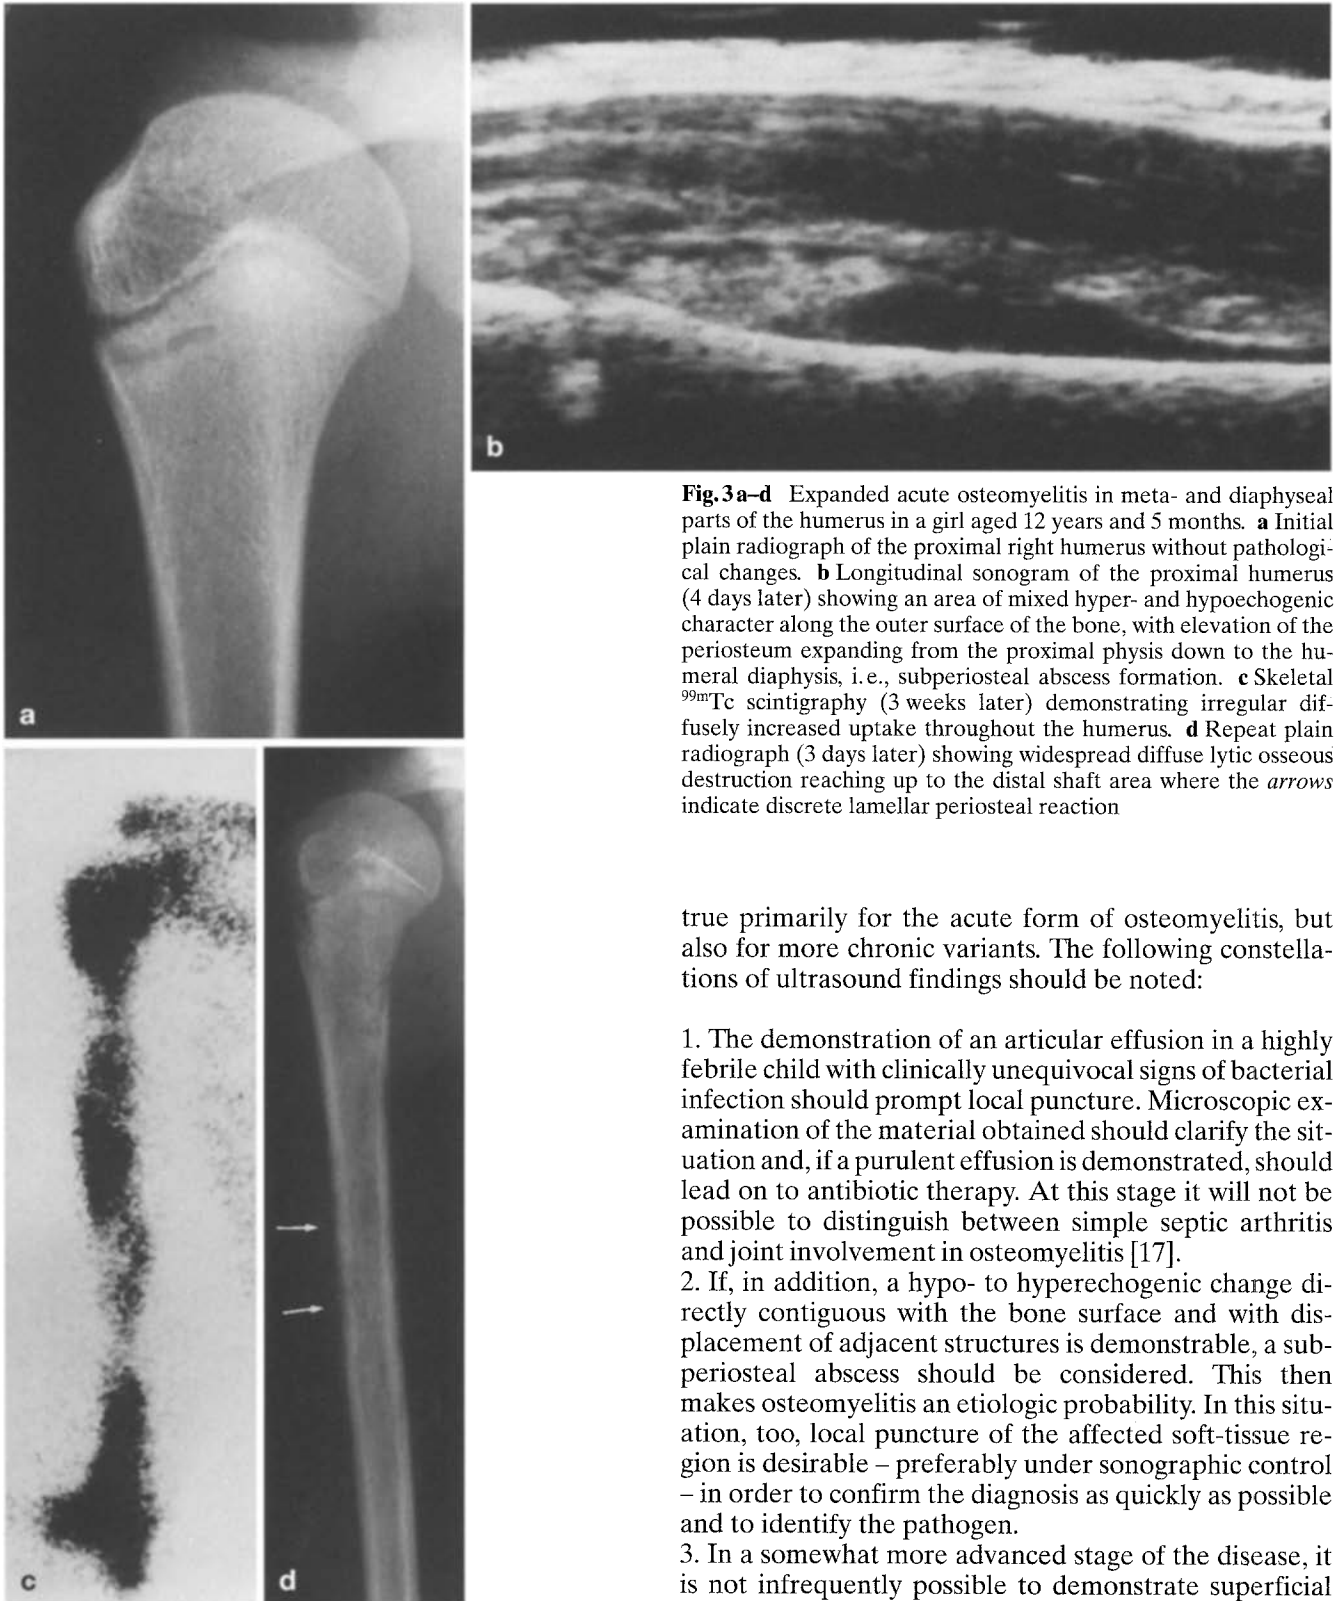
Expanded acute osteomyelitis in meta- and diaphyseal parts of the humerus in a girl aged 12 years and 5 months. a Initial plain radiograph of the proximal right humerus without pathological changes. b Longitudinal sonogram of the proximal humerus (4 days later) showing an area of mixed hyper- and hypoechogenic character along the outer surface of the bone, with elevation of the periosteum expanding from the proximal physis down to the humeral diaphysis, i. e., subperiosteal abscess formation. c Skeletal ^{99m}Tc scintigraphy (3 weeks later) demonstrating irregular diffusely increased uptake throughout the humerus. d Repeat plain radiograph (3 days later) showing widespread diffuse lytic osseous destruction reaching up to the distal shaft area where the arrows indicate discrete lamellar periosteal reaction
